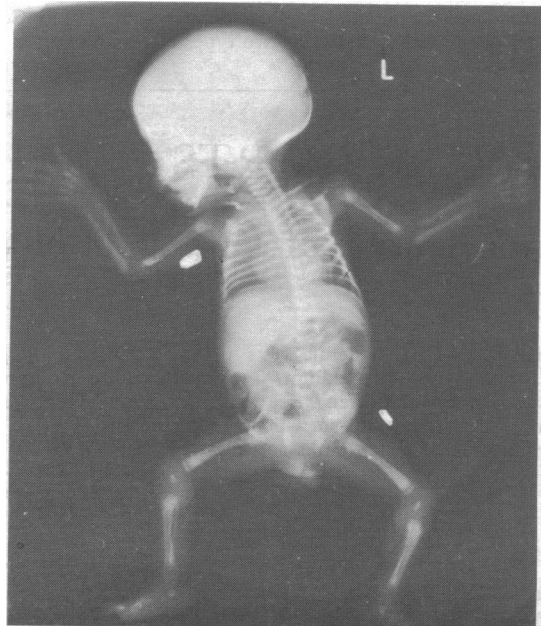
Radiograph on 10th day showing stippling of all epiphyses.
